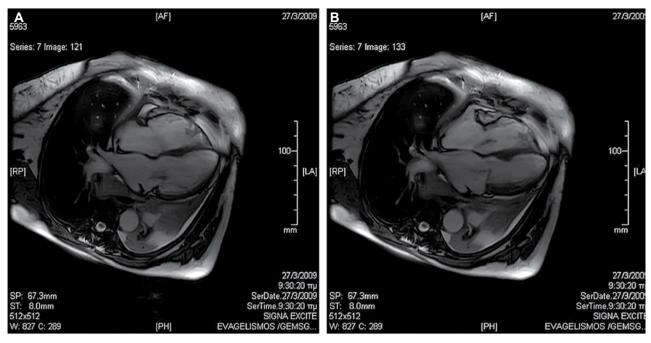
Magnetic resonance imaging of the left ventricle in end-diastole (A) and end-systole (B) in a patient with takotsubo cardiomyopathy (our case).
